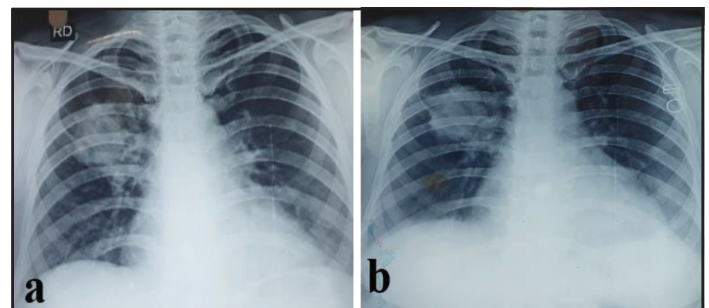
(a and b) - Chest X-ray PA view shows heterogeneous opacity in the right mid zone.
